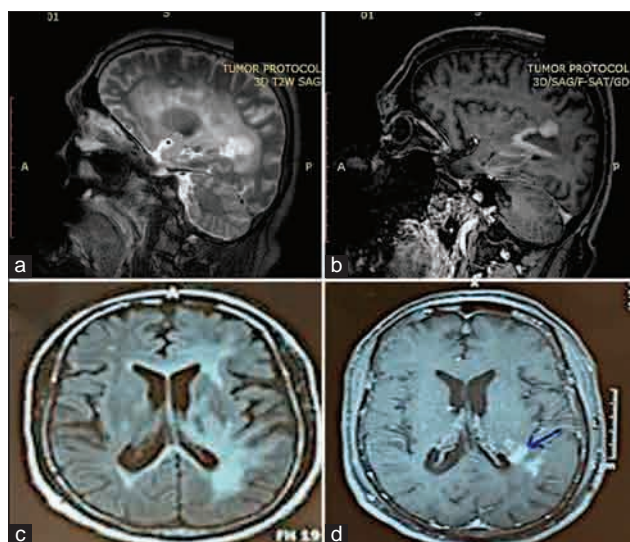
Left parietal periventricular primary central nervous system lymphoma. (a) Sagittal T2w image showing a left periventricular hyperintense lesion in the region of the left atrium. (b and d) Sagittal and axial post-contrast T1w image showing moderate contrast-enhancement. (c) FLAIR sequence showing perilesional edema in the region of left atrium extending up to the region of left thalamus and left frontal horn
